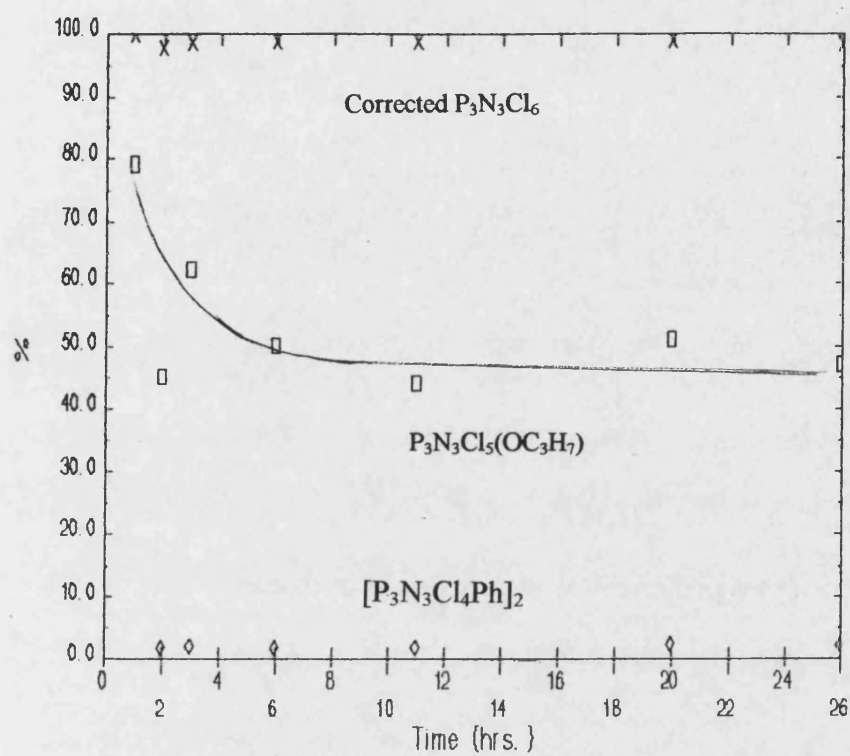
Distribution of products in the ultrasonic reaction of  $P_3N_3Cl_6$  with  $PhMgCl$ .
